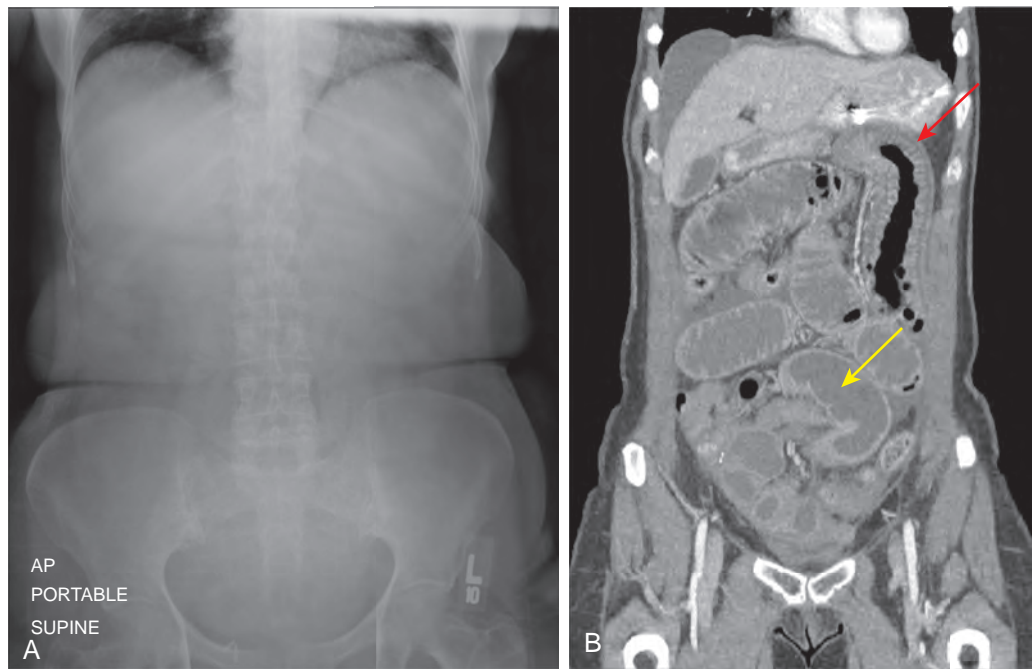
Plain abdominal radiography limitations. A. Supine radiograph of the abdomen shows a gasless abdomen. B. Coronal reformatted CT scan performed several hours later shows a distal small bowel obstruction with fluid-filled small bowel loops (yellow arrow) and an ischemic jejunal loop (red arrow) with mural thickening. If the bowel is completely filled with fluid, plain abdominal radiographs will misjudge the presence and level of small bowel obstruction.
